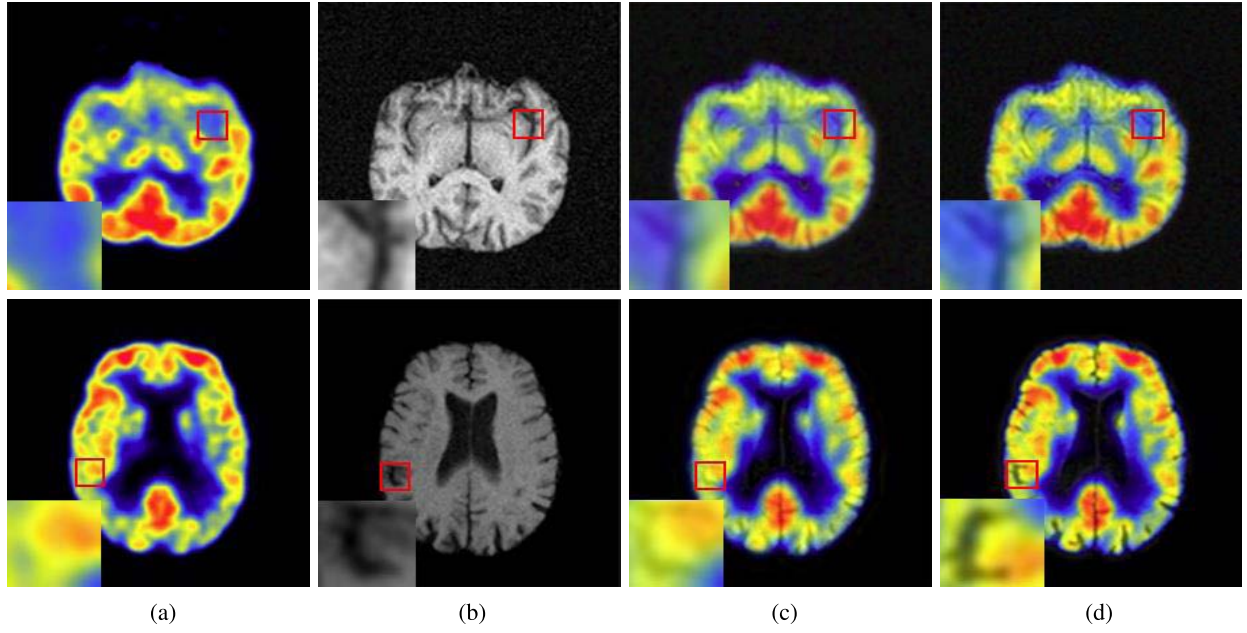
Experimental comparison of PET and MRI image fusion. (a) PET image. (b) MRI image. (c) SR. (d) Proposed method.
